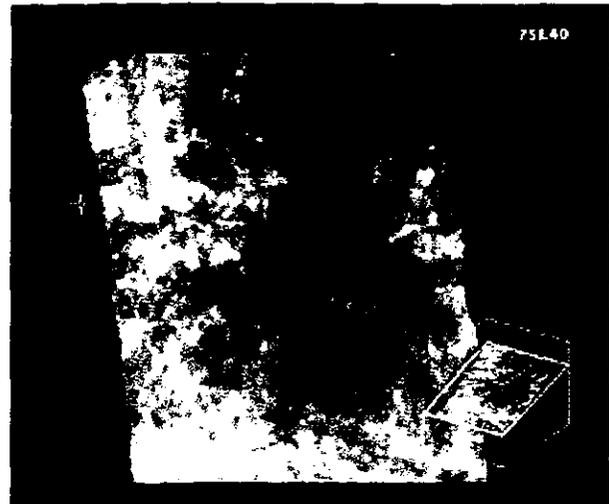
Multi-planner reconstruction image of 3D ultrasound.
